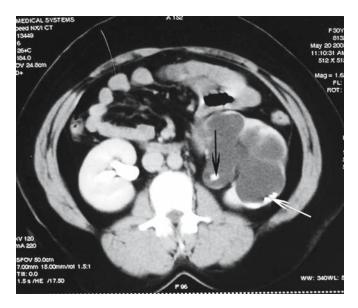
A CT scan shows a left UPJ obstruction in a kidney with an intrarenal pelvis and multiple secondary calculi (arrow)
